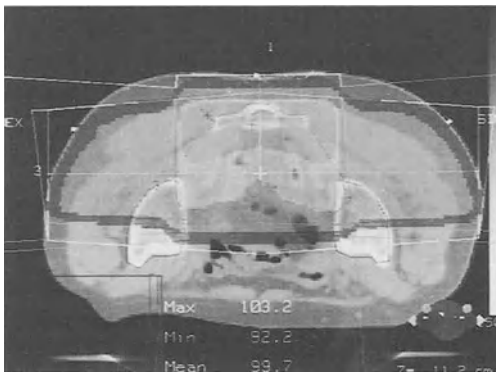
Treatment settings of a patient with locally advanced rectal cancer after abdominoperineal resection. a ap/pa Field of the standard three- or four-field wedge technique; b lateral field of the standard three- or four-field wedge technique; c dose distribution; d three-dimensional CT-guided treatment planning; e dose-volume histogram concerning bladder and target volume; f beam's-eye view after three-dimensional treatment planning (plotted at distance = 68 cm)
